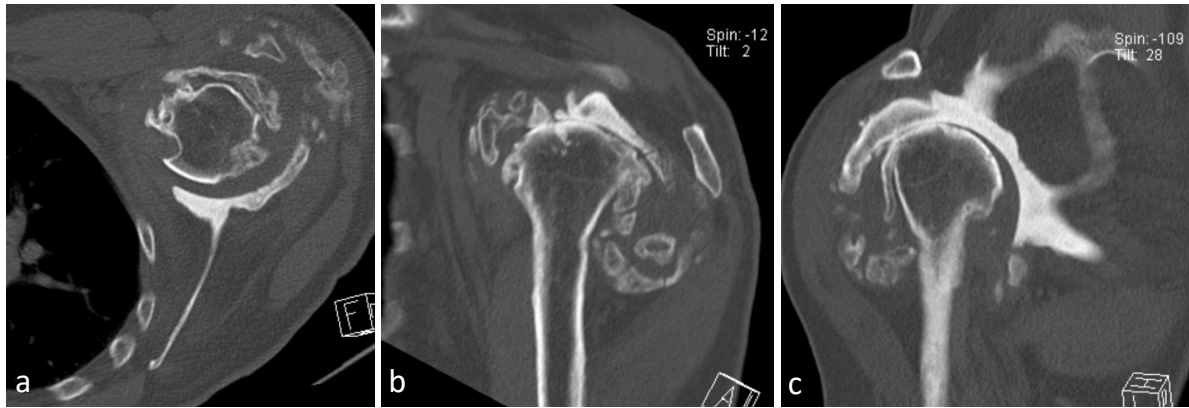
Axial (a), sagittal (b) and coronal (c) reconstructions of left shoulder CT. Joint disorganization is evident, with anterior glenohumeral subluxation and marked bone deformities, with emphasis on the exuberant enlargement of the glenoid, associated with productive bony changes, with sclerosis, osteophytosis and extensive fragmentation.
